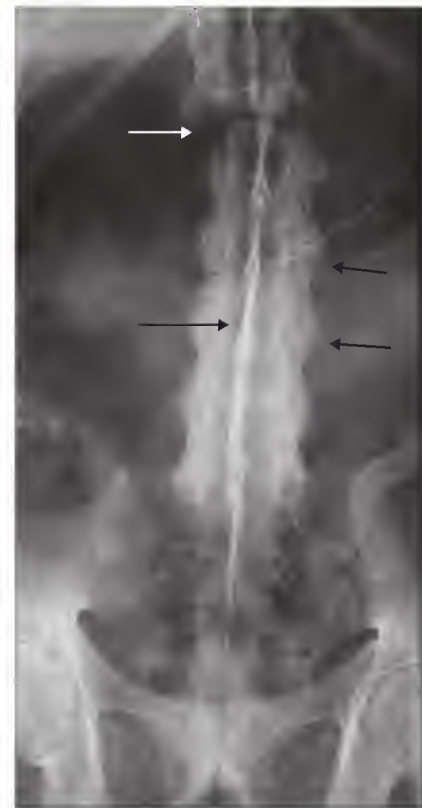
Frontal radiograph of the lumbar spine shows fine bridging bone (syndesmophytes) across the intervertebral disk space (short black arrows) as well as ossification of the posterior interspinous ligaments (long black arrow). This results in a bamboo spine, which predisposes to spinal fractures (white arrow). The sacroiliac joints are fused. (Courtesy Jade Wong, MD.)
